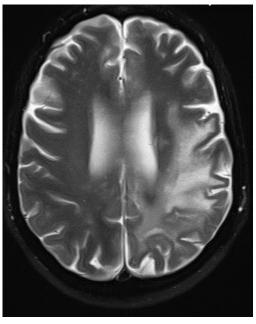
Brain MRI imgaing shows SLE related cerebritis and resolution of previously seen PRES related changes
